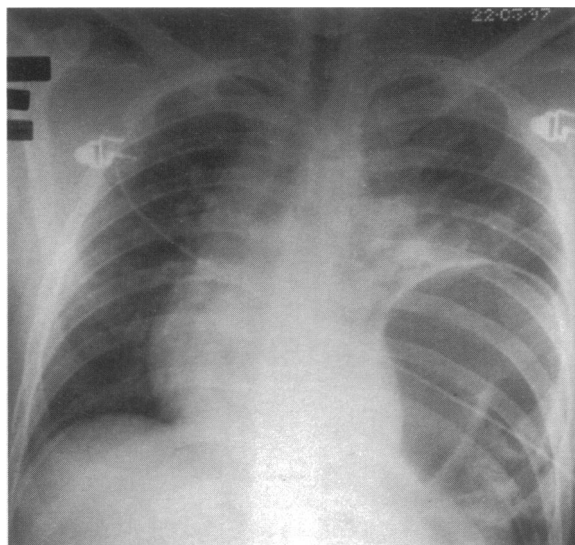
Supine chest radiograph showing visceral herniation into the left hemithorax.
